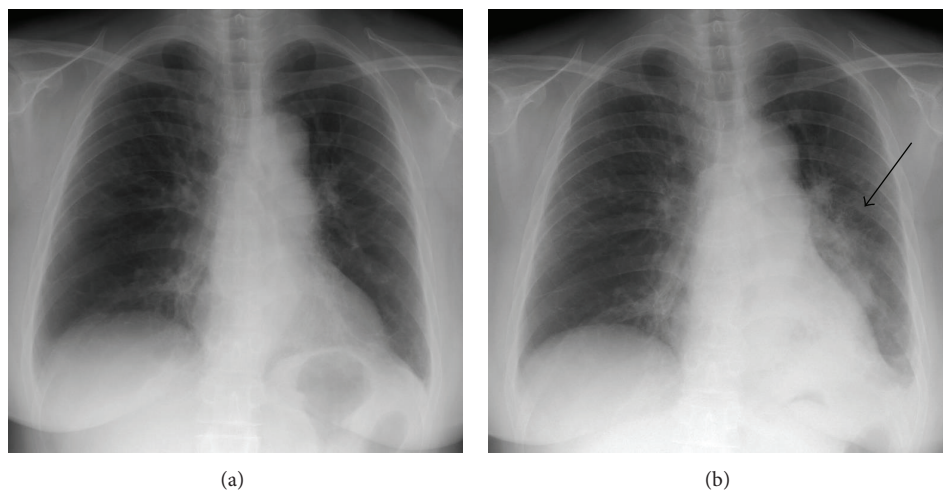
Chest X-ray at the onset of DM (a). Chest X-ray at the lung cancer diagnosis revealing infiltrative shadows in the left lung field 30 years after the onset of DM (b).
